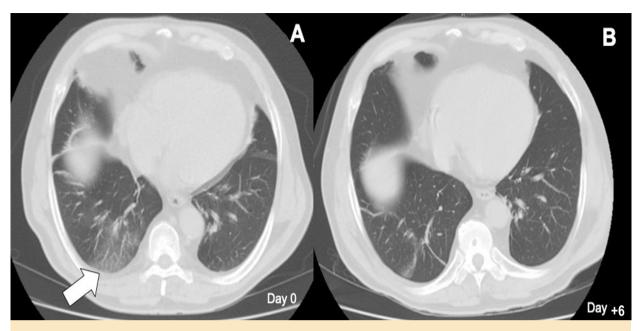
Chest CT findings (Day 0 [A] and Day +6 [B] after transplant) in a patient with positive RT-PCR for SARS-CoV-2 at the time of kidney transplantation.
